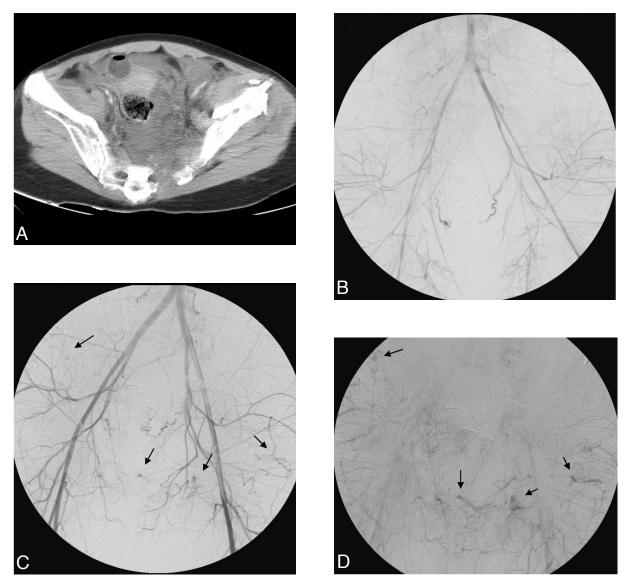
A: The axial late arterial phase CT image demonstrates a large hematoma in the pelvic cavity. B: The conventional angiogram demonstrates small caliber bilateral internal iliac arteries without significant contrast extravasation. C and D: Two days later, angiogram shows multifocal contrast extravasation at peripheral branches of bilateral internal arteries (arrows) that were subsequently embolized by Gelfoam cubes.
